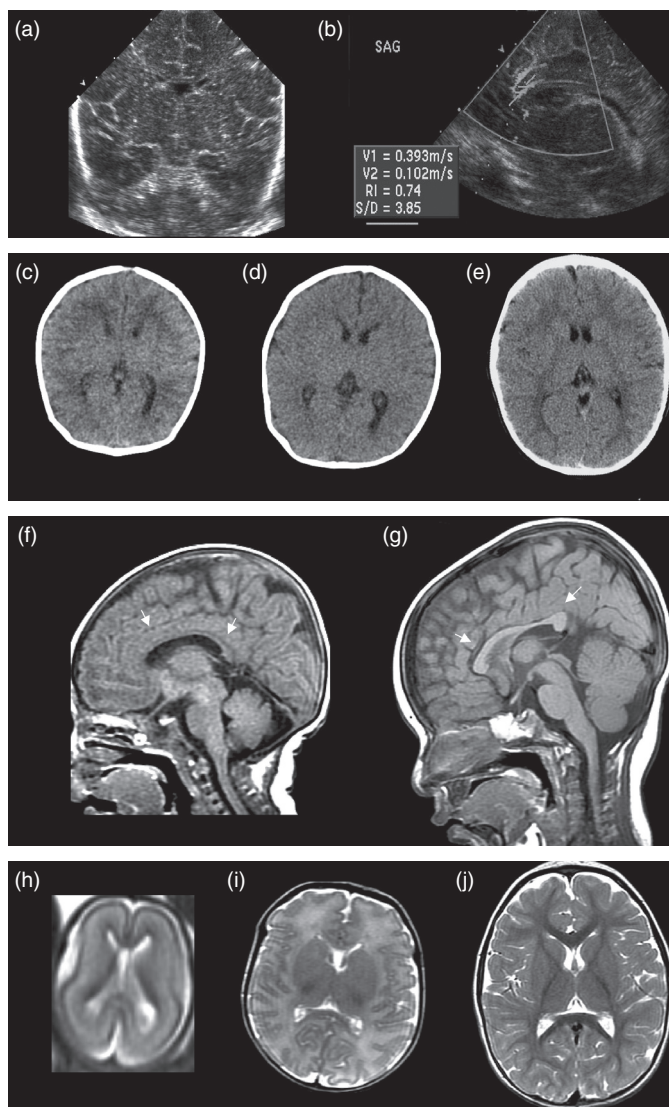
Normal infant and child brain. Ultrasound (US) images of term neonate: (a) coronal US; (b) sagittal US + Doppler with resistive indices (RI). Computed tomography (CT) images of (c) term neonate, (d) 2-month-old infant, and (e) 2-year-old child show progress of maturation, including myelination. Sagittal T1 magnetic resonance images (MRIs) of (f) term neonate and (g) 1-year-old infant show progress in brain growth, myelination of the corpus callosum (arrows), and pituitary maturation. T2 MRIs of (h) 20-week fetus, (i) term neonate, and (j) 2-year-old child show progress in maturation, i.e., decreasing water content, increasing myelination and cortication. See color plate section.
